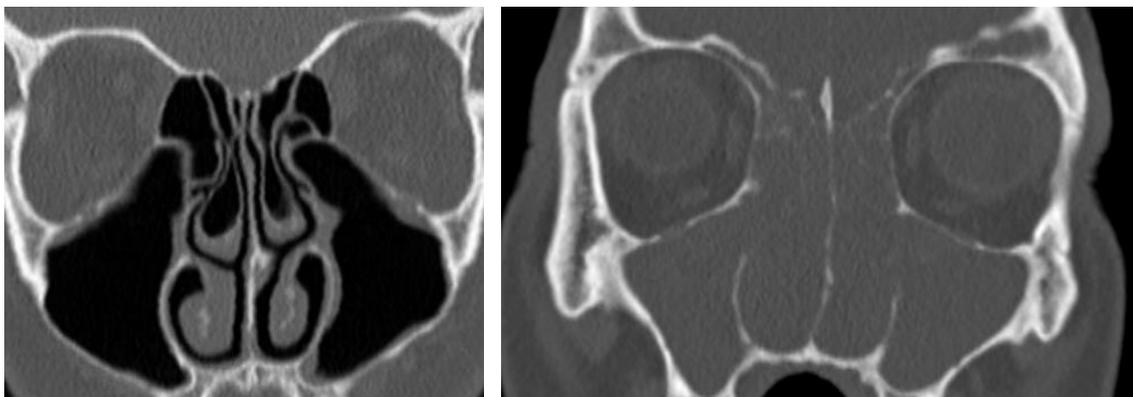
Comparison of cranial CT scans, coronal section plane
